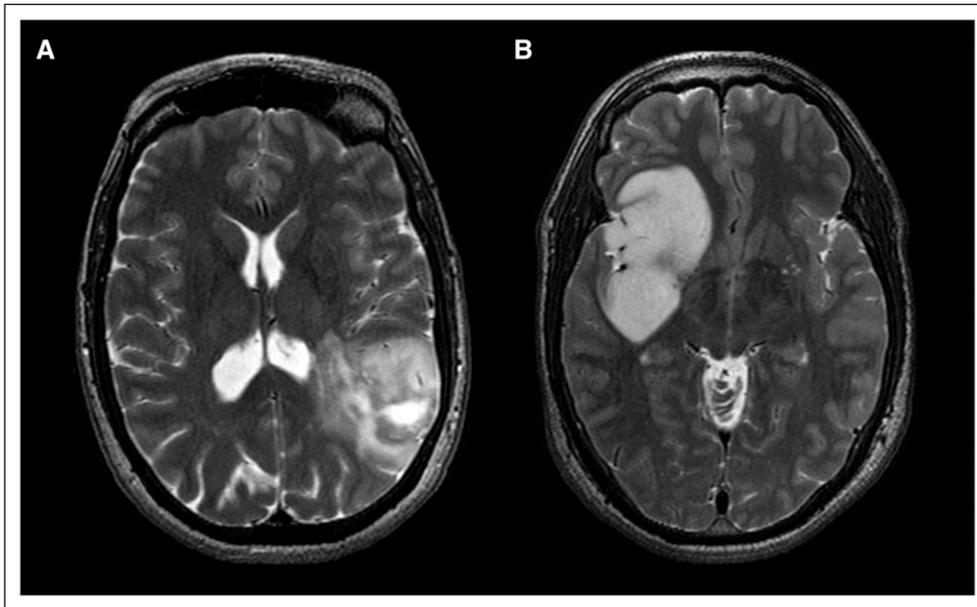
Typical axial T2-weighted magnetic resonance (MR) images of (A) an *IDH*-mut and 1p/19q co-deleted oligodendroglioma, and (B) an *IDH*-mut astrocytoma. Note the heterogeneous signal intensity, cortical involvement, and indistinct border of the oligodendroglioma. In contrast, there is homogeneous signal intensity, a sharp border, and no involvement of the cortex in the astrocytoma.
